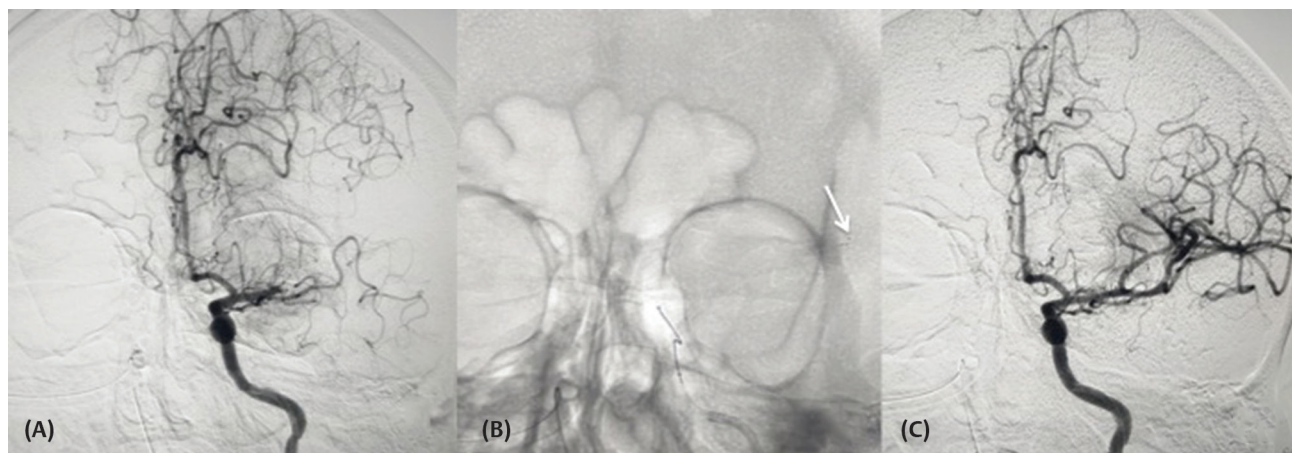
Frontal digital subtraction angiography (DSA) (A, C) and radiography (B) image showing complete recanalization of middle cerebral artery (MCA) branches following mechanical thrombectomy using stentriever (arrow pointing to its distal aspect) in acute ischemic stroke due to MCA occlusion.
